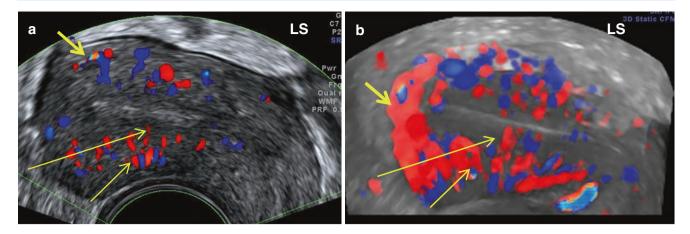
Normal vasculature of myometrium on (a) colour Doppler and (b) on 3D glass body display. *Short thick arrows* showing arcuate vessels, *medium-sized arrows* showing radial vessels and *long arrows* showing spiral vessels
